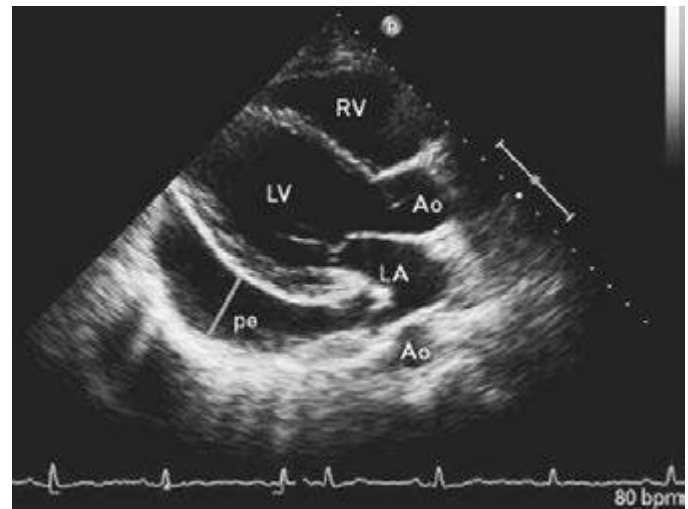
Two-dimensional echocardiogram in lateral view in a patient with a large pericardial effusion. Ao, aorta; LV, left ventricle; pe, pericardial effusion; RV, right ventricle. (From M Imazio: *Curr Opin Cardiol* 27:308, 2012.)
